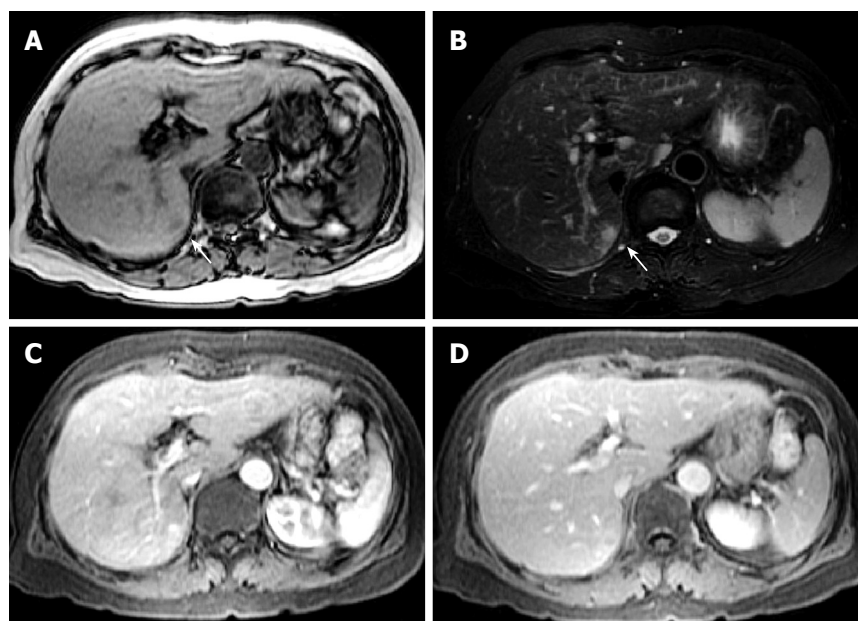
Magnetic resonance imaging (MRI) showing a 10 mm nodule in segment 7. A: A hypointense nodule on T1-weighted images; B: A hyperintense nodule on T2-weighted images; C: A hyperintense nodule in the early phase after injection of contrast medium; D: A hypointense nodule in the late phase after injection of contrast medium.
